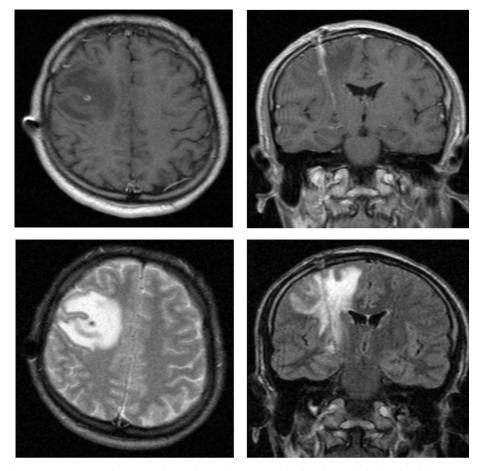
Patient 2. T1, T2 and FLAIR MRI showing large edema surrounding the right DBS lead along the whole trajectory.
